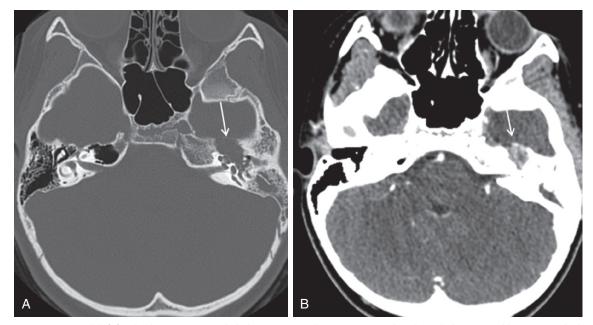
Patient presenting with left facial palsy: Hemangioendothelioma at surgical resection. A, Axial CT through the temporal bone set on the bone window setting demonstrates a large destructive mass of the left petrous bone at the level of the geniculate ganglion/first turn of the facial nerve (*arrow*). Opacification of the left middle ear and mastoid is related to extension of the mass into the eustachian tube. B, Contrast-enhanced CT on the soft tissue window setting at the same level delineates heterogeneous enhancement of the mass (*arrow*).
